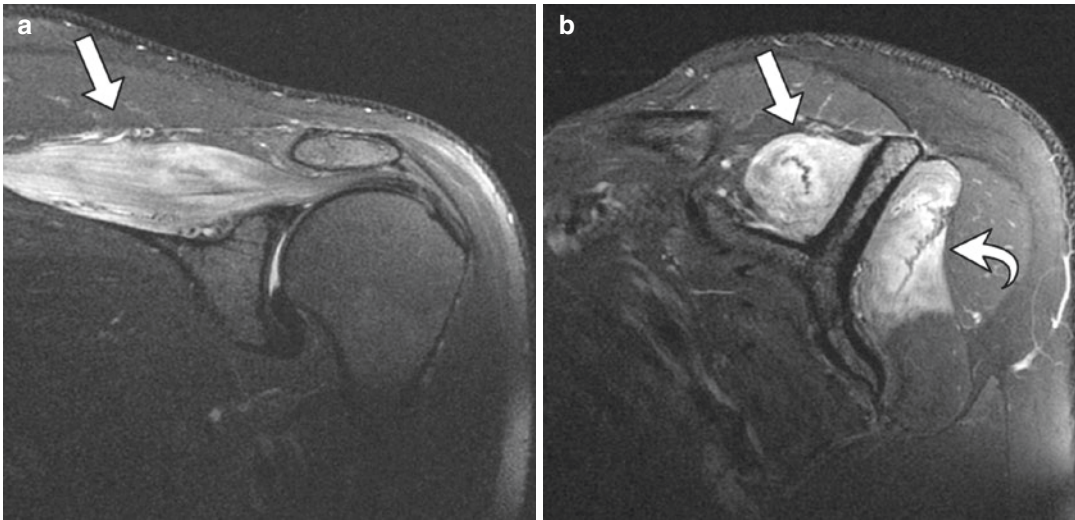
37-Year old male sagittal T2-weighted fat-suppressed coronal (a) and sagittal (b) oblique showing diffuse neurogenic edema of supraspinatus (arrow) and infraspinatus (curved arrow) muscles. The patient had no
